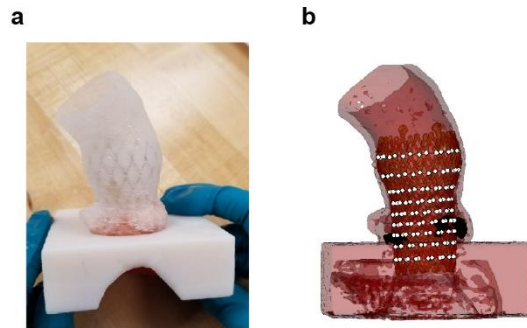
Implantation of the prosthetic valve in the 3D printed aortic root model. (a) Implanted valve in the 3D printed aortic root model mounted in the fixture. (b) Corresponding scan of the 3D printed model constructed from CT imaging and the marked 9 node levels used for frame analysis.
